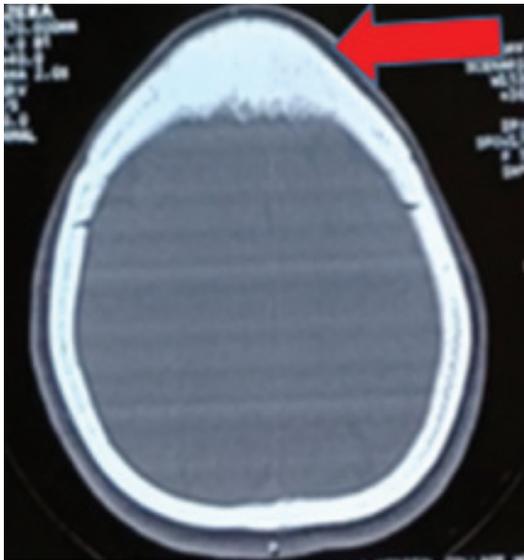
Non-contrast computed tomography scan showing hyperdense frontal bony lesion
